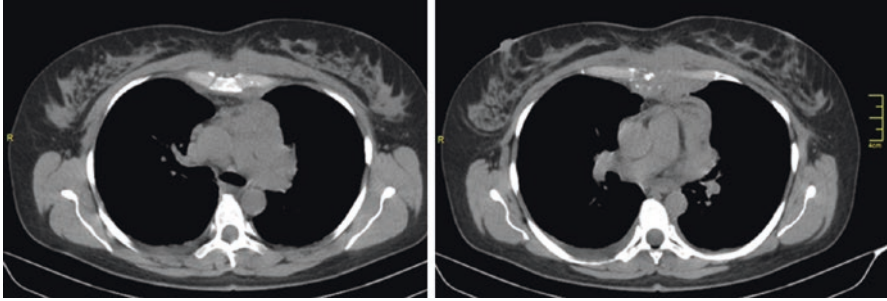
Chest CT without contrast: Hodgkin's lymphoma infiltrating the breastbone
